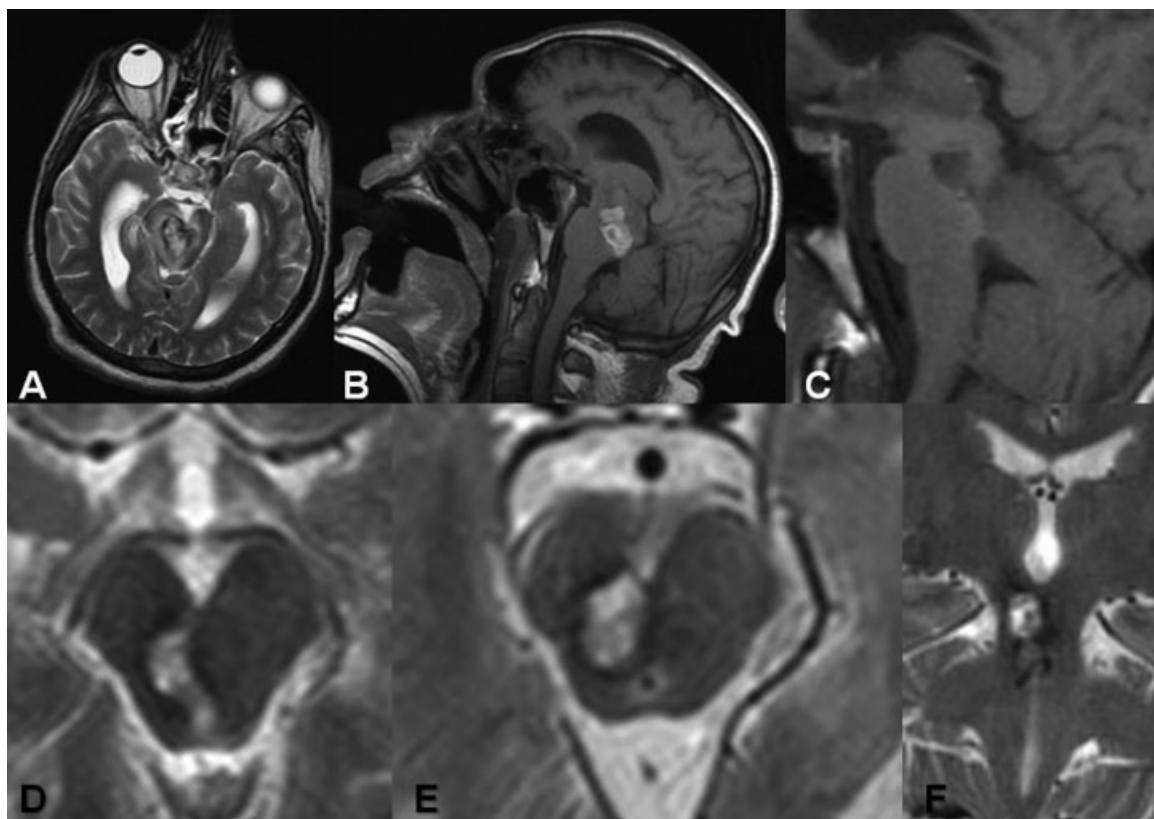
(A) Axial T2-weighted and (B) sagittal T1-weighted brain MRI of our patient demonstrating a bled cavernoma located in the posterior of the right mesencephalon and pons, extending through the right tectum and tegmentum and right nucleus rubra and reaching the substantia nigra. (C) Sagittal T1 weighted, (D) axial T2 weighted MRI at the level of the superior colliculus, (E) axial T2 weighted MRI at the level of the inferior colliculus, and (F) coronal T2-weighted MRI after the microsurgical resection showing the cavity and gliosis in the previous location of the cavernoma in the brainstem. MRI, magnetic resonance imaging.
